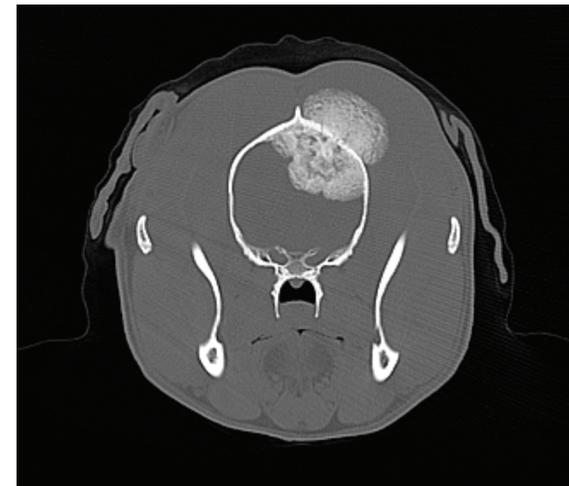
Computed tomography of case 2 shows a large mass at the height of the skull bone with inward expansion and compression of the cerebral hemisphere.
